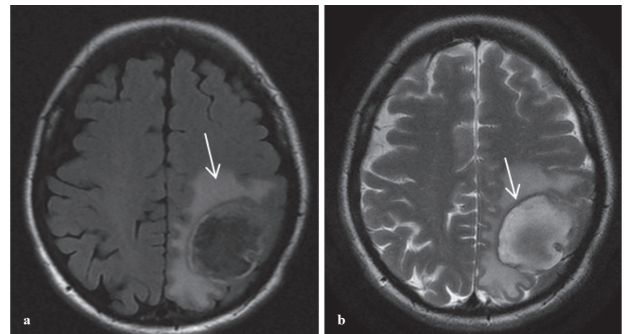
Axial FLAIR (a) and T2WI (b) show a well circumscribed lesion in the left parietal lobe with surrounding edema (arrow in a). The lesion appears with intermediate signal intensity. T2WI image shows the dual-rim sign (arrow in b).
